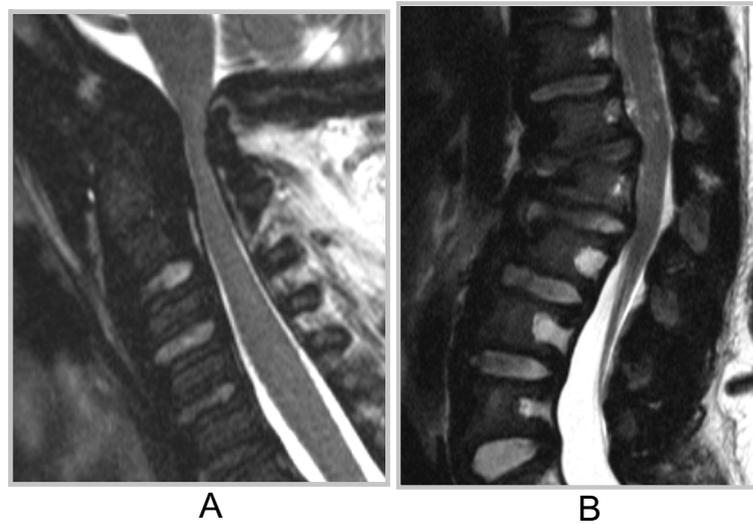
Sagittal T2-weighted magnetic resonance imaging scans showing spinal cord compression in (A) the cervico-cranial region due to peri-odontoid soft tissue mass and (B) the thoraco-lumbar region due to beaked vertebrae.
